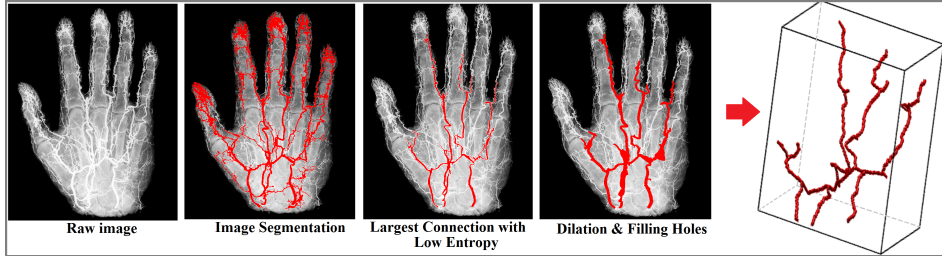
3D reconstruction from stereo X-ray images of human hand
